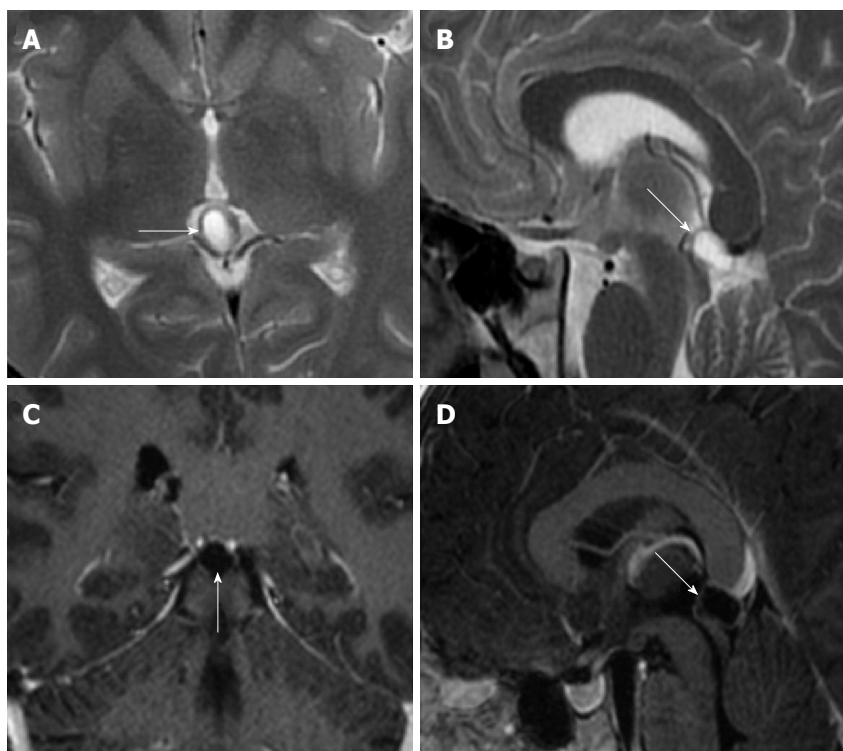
Eighteen years old male patient with typical pineal cyst (patient No. 43). A: Axial plane T2 weighted magnetic resonance imaging (MRI); B: Sagittal plane T2 weighted MRI; C: Axial plane T1 weighted contrast-enhanced MRI; D: Sagittal plane contrast-enhanced MRI. Typical pineal cyst is shown in the pineal region with unilocular homogeneous internal structure (arrows, A, B, C and D); Peripheral rim-like contrast-enhancement is shown (arrow, C and D).
